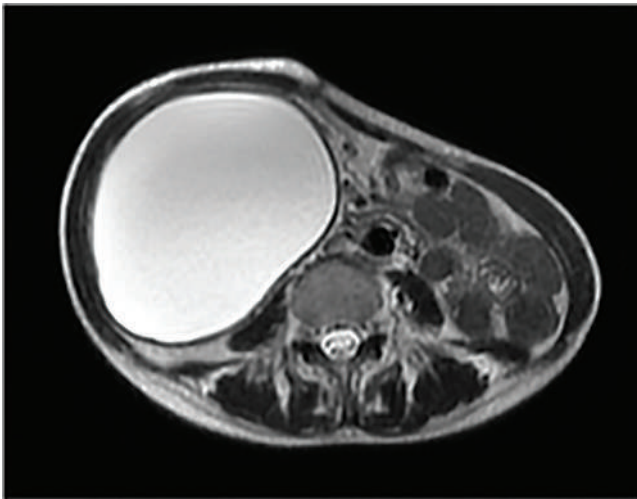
Hepatocyte-specific MRI (axial).
